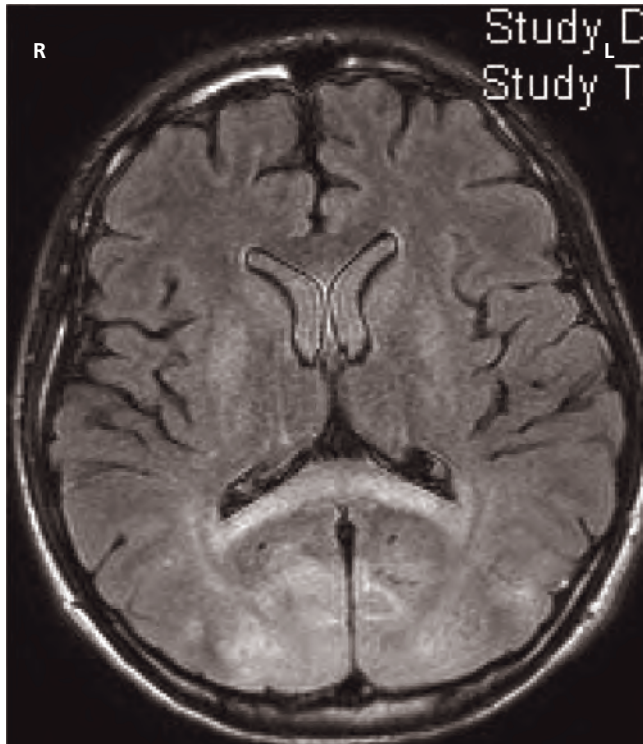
Global ischaemic-hypoxic brain lesions (T1-weighted axial MRI).
